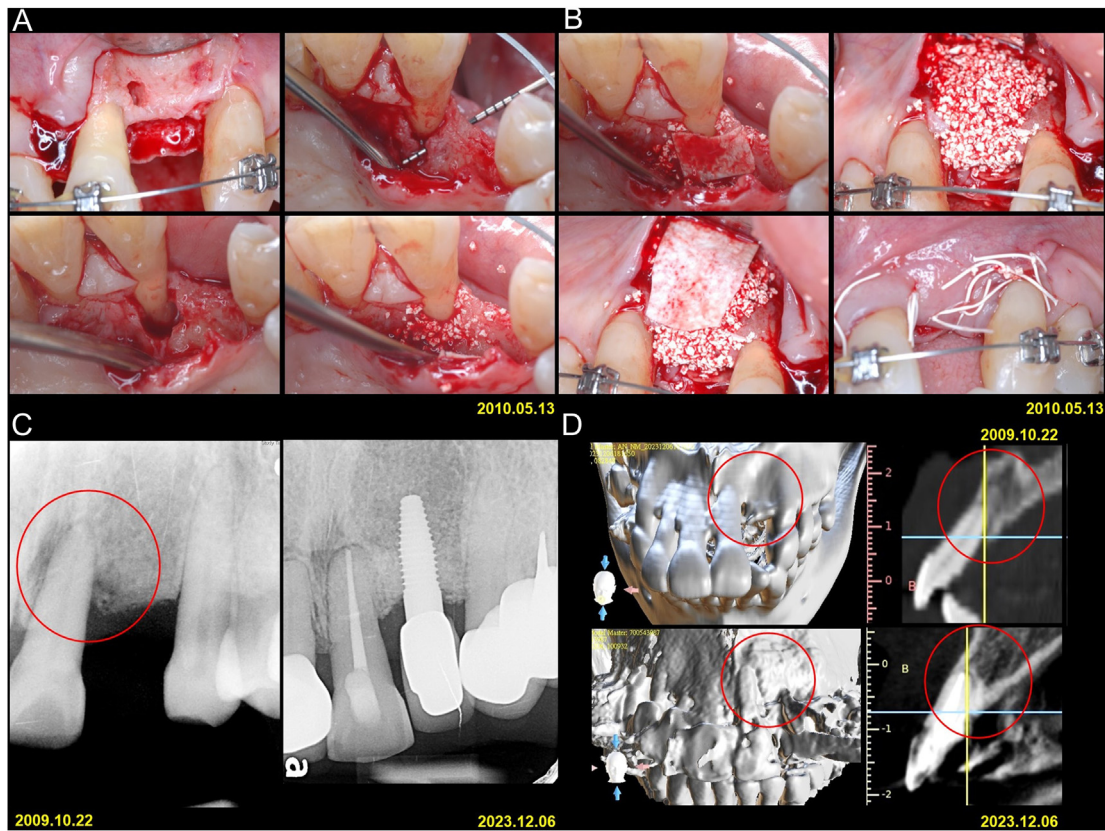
Case 3 involves a 59-year-old female patient diagnosed with Stage IV periodontitis, whose chief complaint is anterior teeth flare-out and missing teeth. The intrabony defect on the palatal side of tooth #21 extended to the apex and penetrated to the buccal side of tooth #22 (Fig. 4A). Periodontal regenerative surgery was performed on #21, while guided bone regeneration surgery was conducted for #22. The intrabony defect of #21 and the horizontal ridge defect of #22 were filled with synthetic bidirectional calcium phosphate bone grafts and covered with absorbable polylactic acid membranes (Fig. 4B). The orthodontic wire (0.014 Cu–Ni–Ti round wire) was inserted immediately after the flap was sutured to initiate orthodontic treatment. Both periapical radiographs taken initially and at the last follow-up (Fig. 4C) and a cone-beam computed tomography (CBCT) scan performed 14.5 years after periodontal regenerative treatment (Fig. 4D) revealed complete filling of the intrabony defect on the palatal side of tooth #21 and the transosseous defect on the buccal side of tooth #22, accompanied by an increase in bone density.
